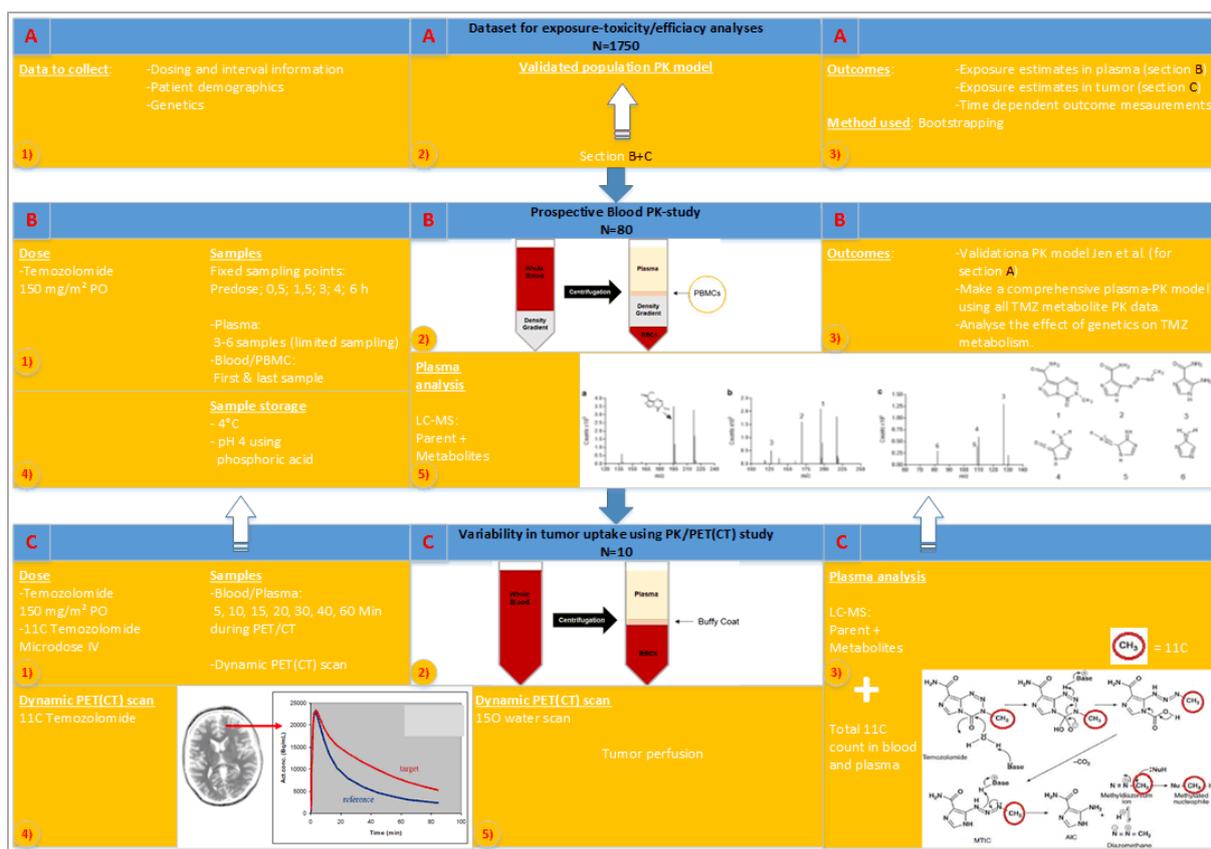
Overview of the PK-PD study (section A), PK study (section B) and PET(CT)-PK study (section C).
